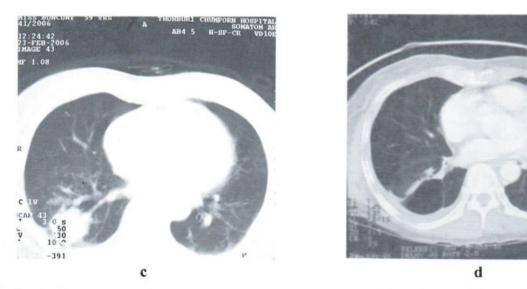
c,d CT scans (c,d). The treated mass were demonstrated as a thin wall cavity (d) replacing the tumor mass at the lateral basal segment of RLL (c) after 2 month followed up. Only soft tissue thickening at the anterior wall that had not been obtained for tissue analysis. Same degree of pleural effusion and thickening is demonstrated.
